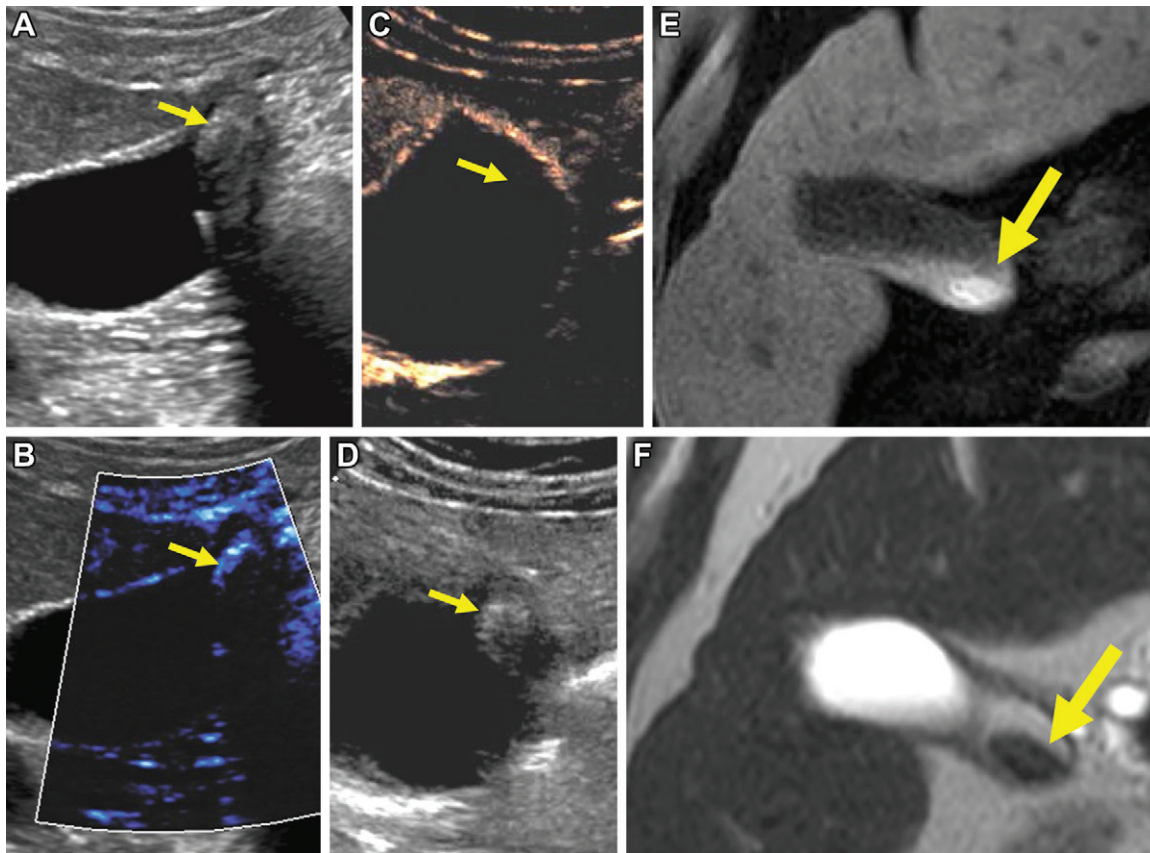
Tumefactive sludge proven to be avascular at contrast-enhanced US (CEUS). (A) Gray-scale US image of the gallbladder shows a polypoid mass (arrow) at the fundus of the gallbladder. (B) Flow-sensitive Doppler technique image shows peripheral artifact (arrow) but no definite internal vascularity. (C) CEUS and (D) gray-scale US images in the transverse oblique plane show no internal enhancement (arrows), consistent with tumefactive sludge. (E) T1- and (F) T2-weighted MRI scans obtained 6 months later show intrinsic high T1 signal intensity and low T2 signal intensity (arrows). MRI findings are concordant with CEUS findings of tumefactive sludge and interval formation of a gallstone.
